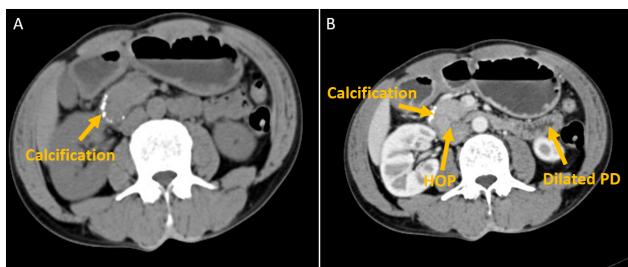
Axial sections: A) Plain CT scan showing presence of hyperdense calcific lesion in the head of the pancreas. B) CECT showing bulky head of pancreas (HOP) with features suggestive of chronic calcific pancreatitis, dilated pancreatic duct, and presence of foci of calcification.
